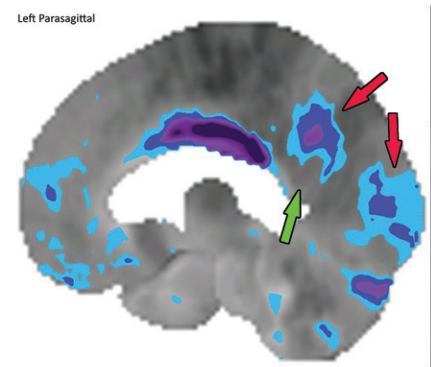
Dementia with Lewy bodies. (a) Axial ^{123}I -ioflupane SPECT image in a patient with memory loss shows decreased left striatal uptake with a period appearance (red arrow), confirmatory of a parkinsonian neurodegenerative disease. Note the normal right striatal uptake with a comma appearance (green arrow), representing preserved putaminal uptake. (b) Sagittal ^{18}F -FDG PET image shows subtle decreased uptake within the occipital region (arrow). (c) Parasagittal computer-generated map shows a statistically significant decrease in FDG uptake in the precuneus and occipital lobe (red arrows). Note that the posterior cingulate gyrus is spared (cingulate island sign), which is more readily apparent on the computer-generated map (green arrow) than on the ^{18}F -FDG PET image. These findings corroborate the diagnosis of DLB.
